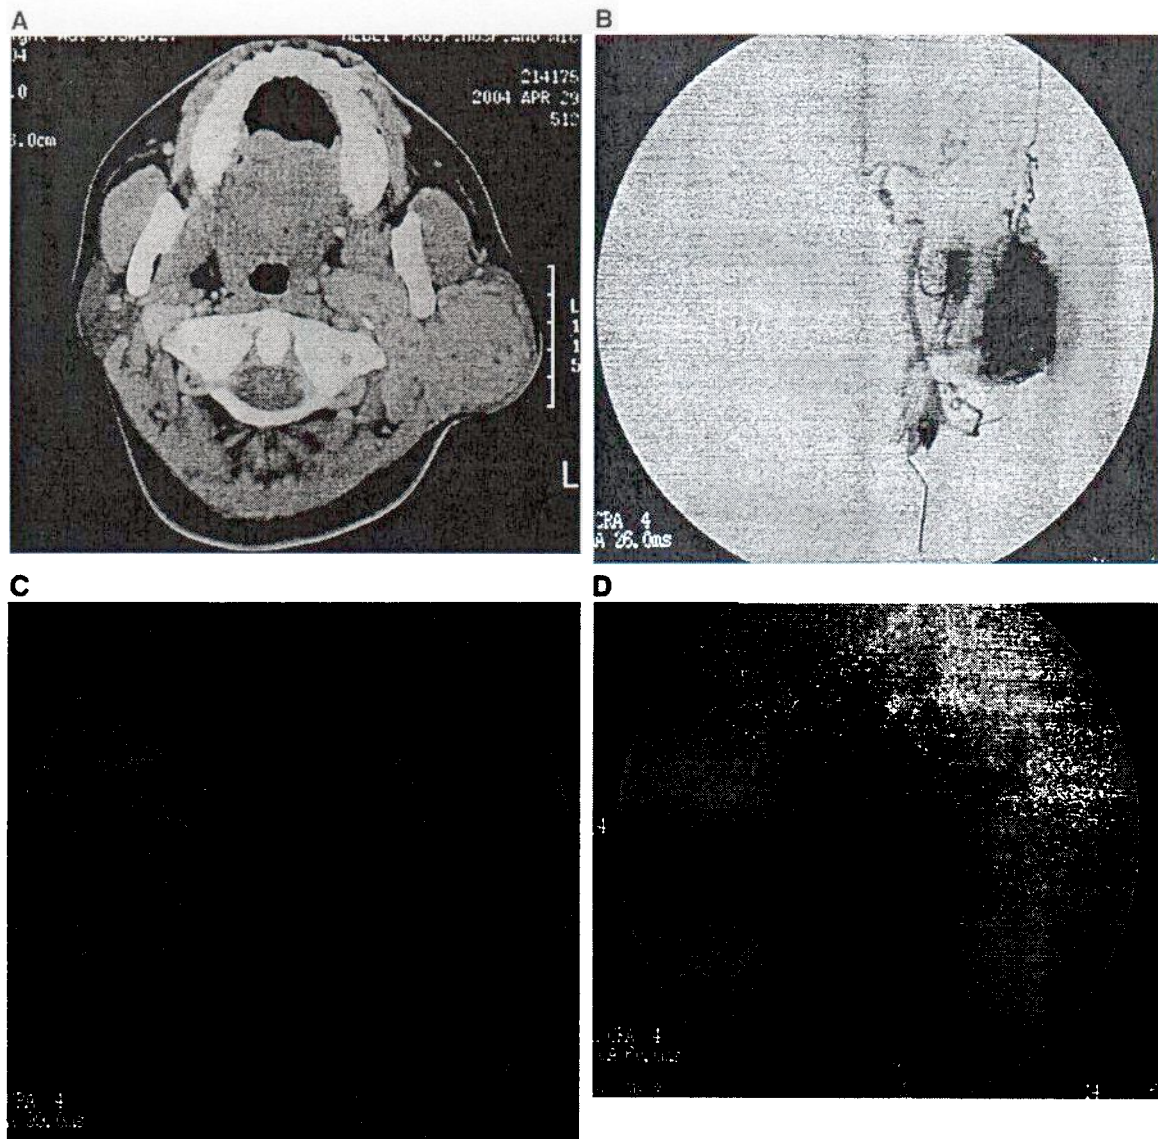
A, Axial CT of a 40-year-old woman showed an irregular large mass involving the parotid and parapharyngeal space. B, Left common carotid arteriography, frontal view, showing the large tumor blush at the parotid area. C, Lateral view of the same arteriography. D, The tumor disappeared after PVA and Gelfoam embolization through the posterior auditory artery and small feeders of the ECA trunk.
